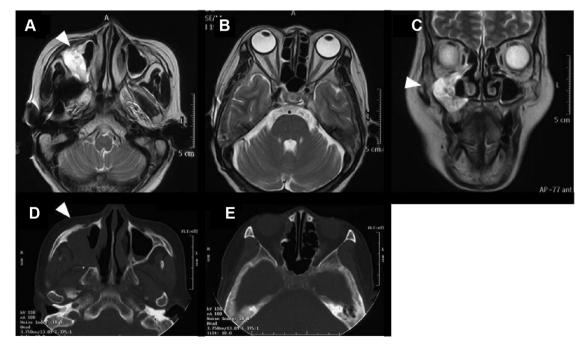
(A-E) T2-weighted MRI and CT images of the patient after 4 cycles chemoradiation therapy, the lesion showed decreased volume and changed intensity on these images.
